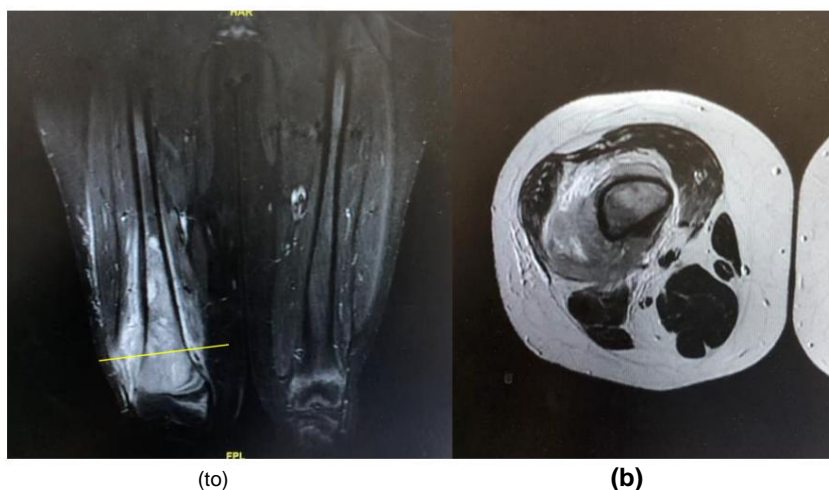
Images obtained from the initial study with MRI of the right thigh (a) coronal section; (b) and axial section.
